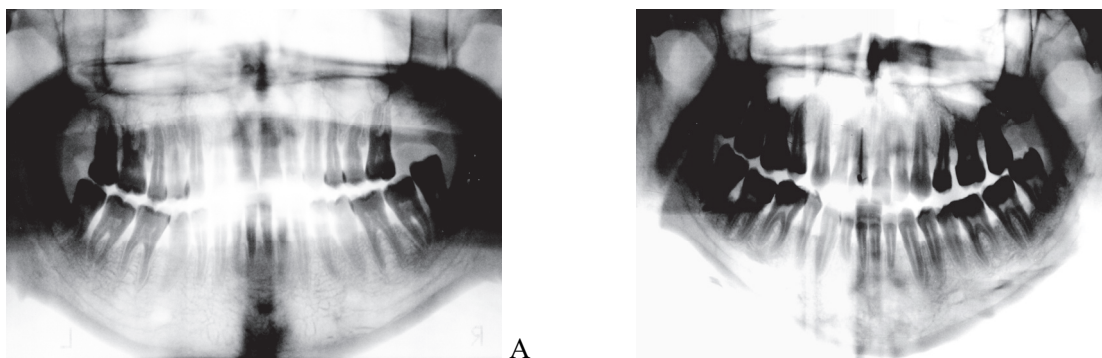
Orthopantomograms. A – Orthopantomogram of a patient with II degree periodontitis. Uniform horizontal atrophy of interalveolar septa, osteosclerosis of cancellous bone, cortical plate with signs of minor osteoporosis, stones in pulp chambers of molars, narrowing of periodontal ligament spaces in most teeth. B – Orthopantomogram of a patient with generalized I–II degree periodontitis. Recession of gums, atrophy of gingival papillae, uneven horizontal and vertical destruction of interalveolar septa, osteoporosis of cancellous bone of interdental septa with zones of osteosclerosis, destruction of cortical plate on alveolar ridges and partially from the sides, expansion of periodontal ligament spaces around teeth.
